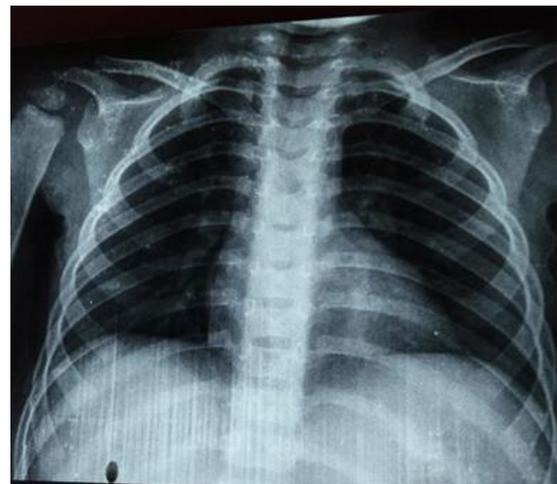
Front chest X-ray without abnormalities.
